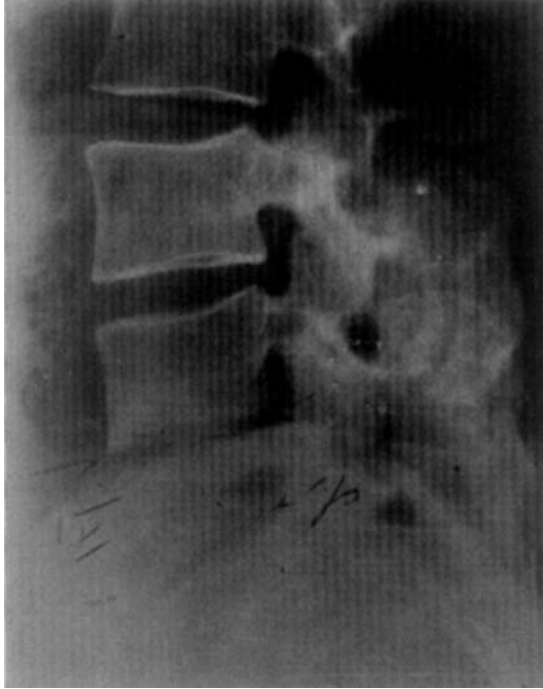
Case 46. Simultaneous lateral radiograph showing strong fusion round the spinous processes.
